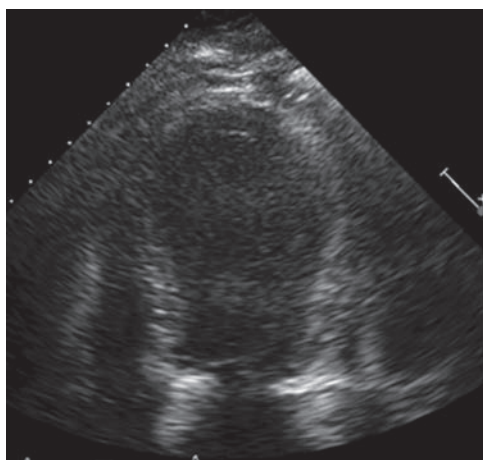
Transthoracic echocardiogram revealing apical ballooning shortly after chest pain episode.
